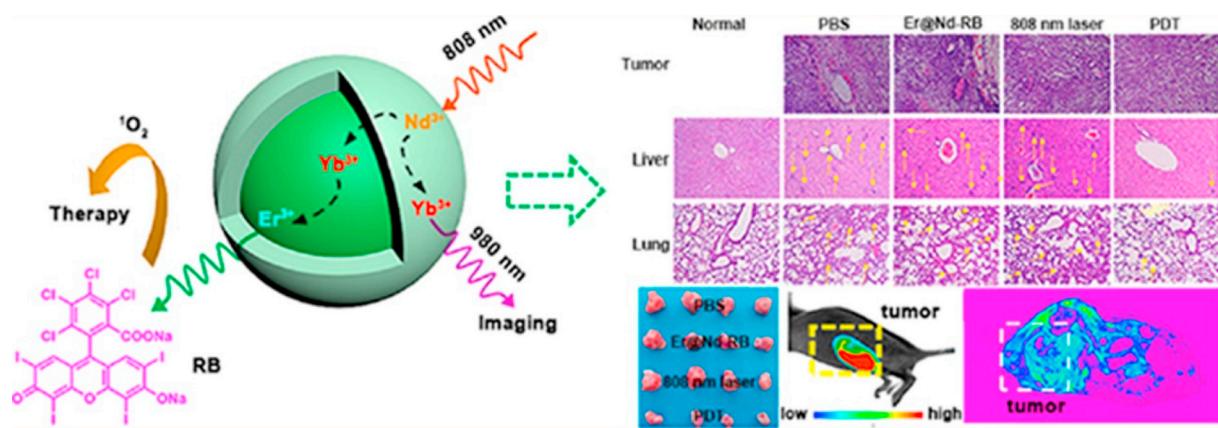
UCL/MRI imaging-guided tumor therapy. Reprinted with permission [124]. Copyright 2016, American Chemical Society.
